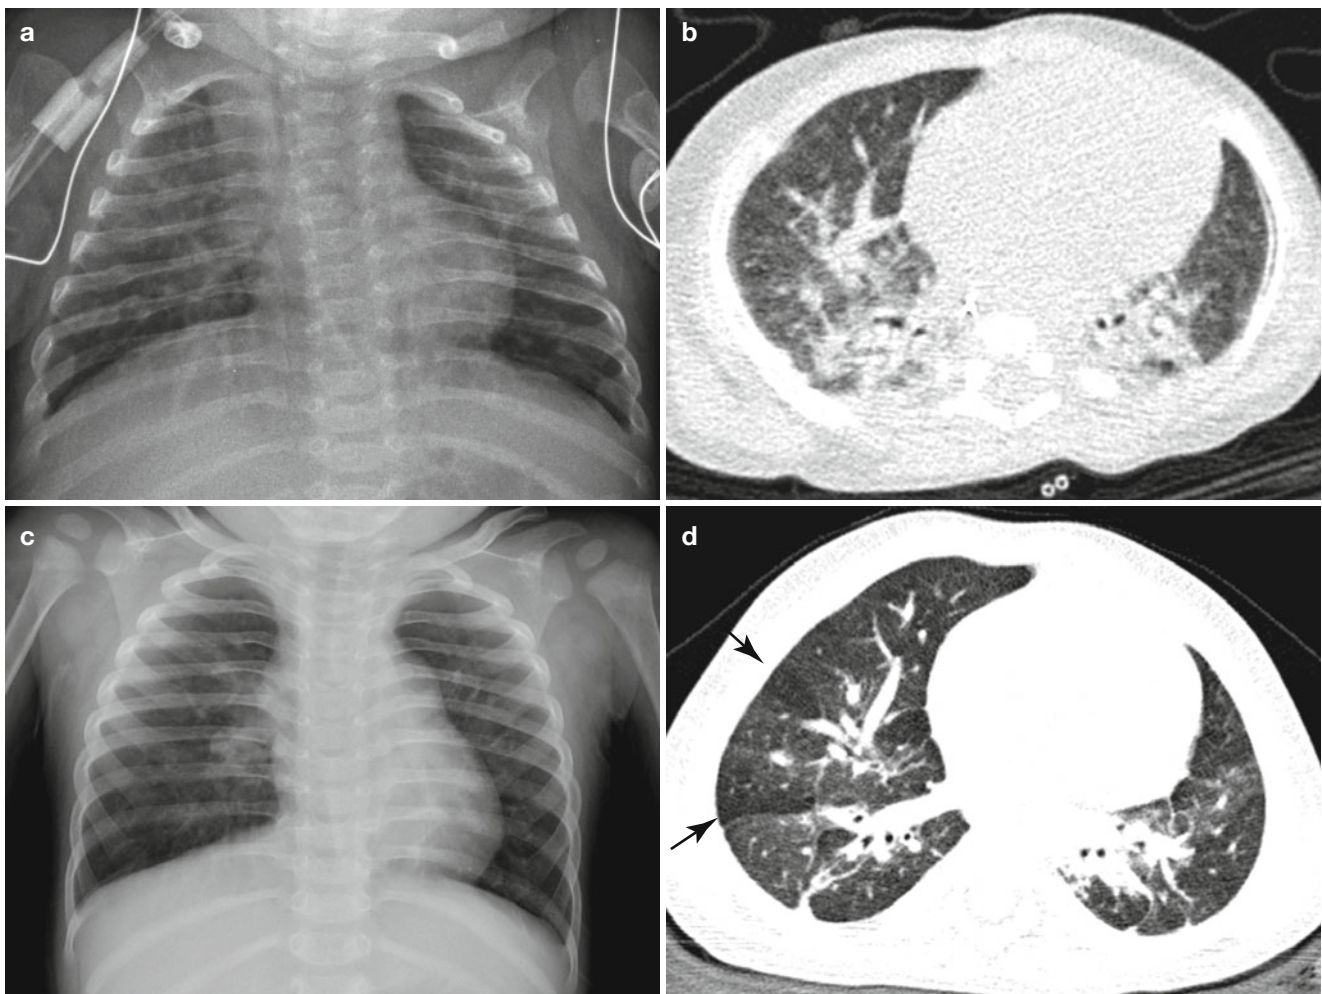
Gradual radiologic improvement of BPD in a pre-term infant born at a gestational age of 30 weeks. (a) Frontal chest radiograph at 3 months of age shows coarse interstitial opacities and overall mild hyperinflation. (b) CT scan obtained at the same time shows multifocal atelectasis and fibrotic opacities, suggestive of BPD. (c) Follow-up chest
